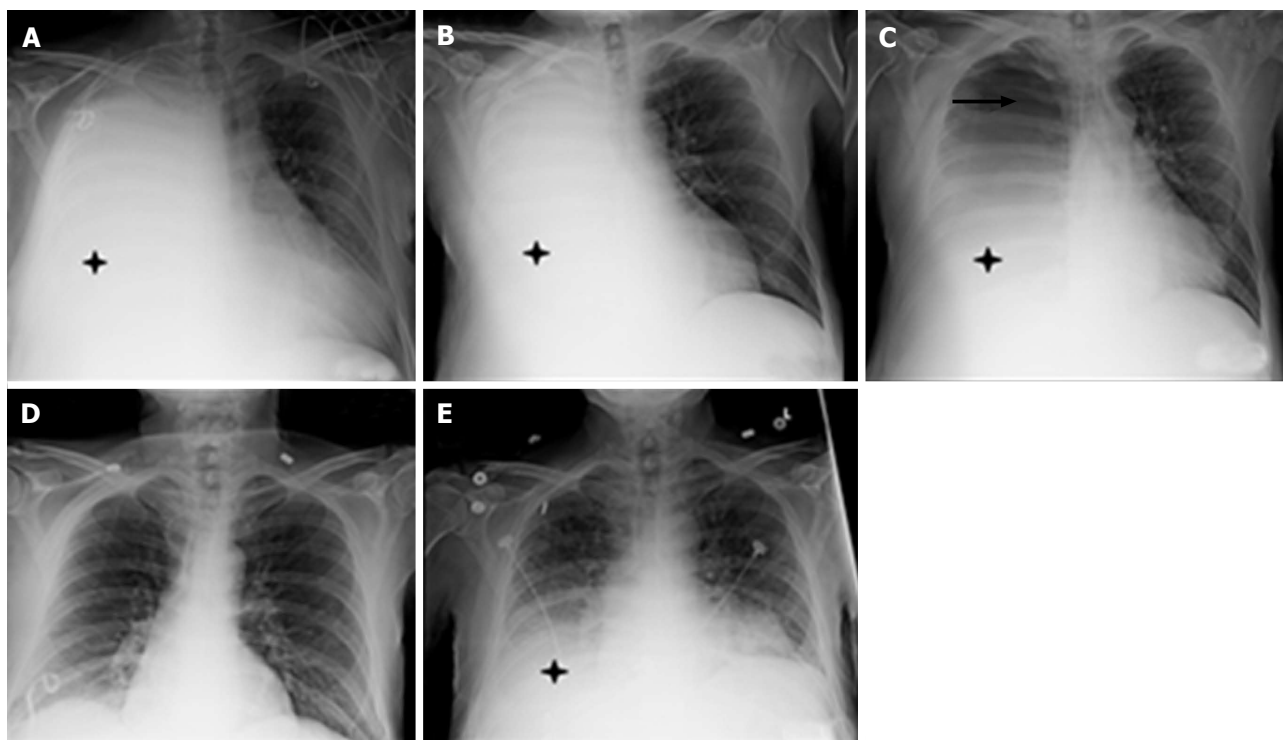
Serial chest radiographs. A: Day 0; B: Day 3; C: Day 4; D: Day 7; E: Day 26. A-C, E: Effusion (asterisks); C: Pneumothorax (arrow).
